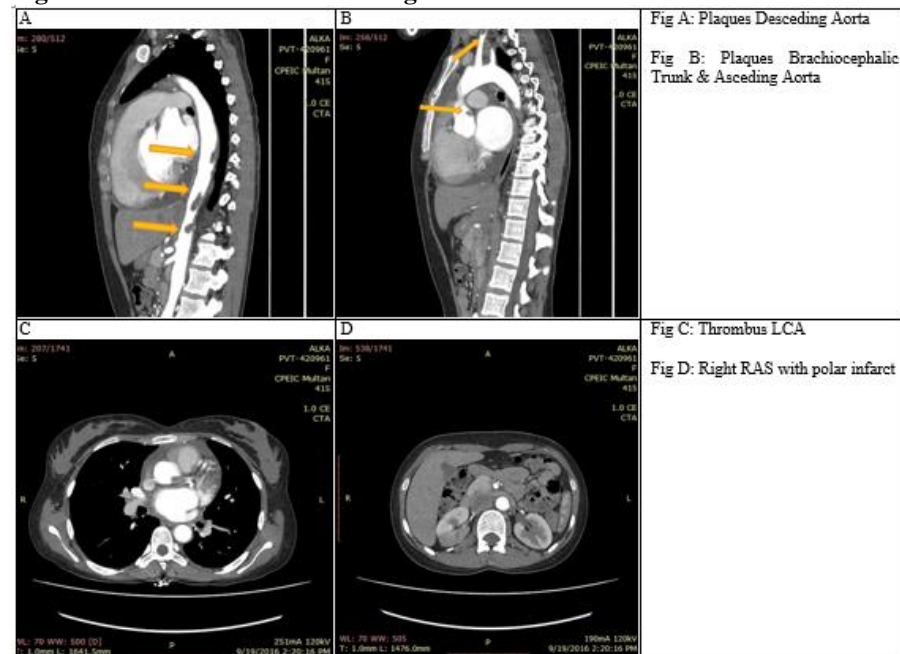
CTA Pictorial Findings of Patient B
